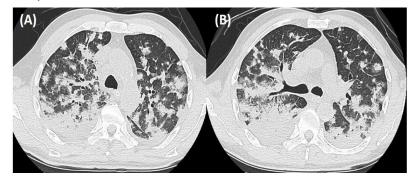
(A)(B) Different cross-section views of chest computed tomography on admission day with diffuse septic emboli and bilateral consolidations.
